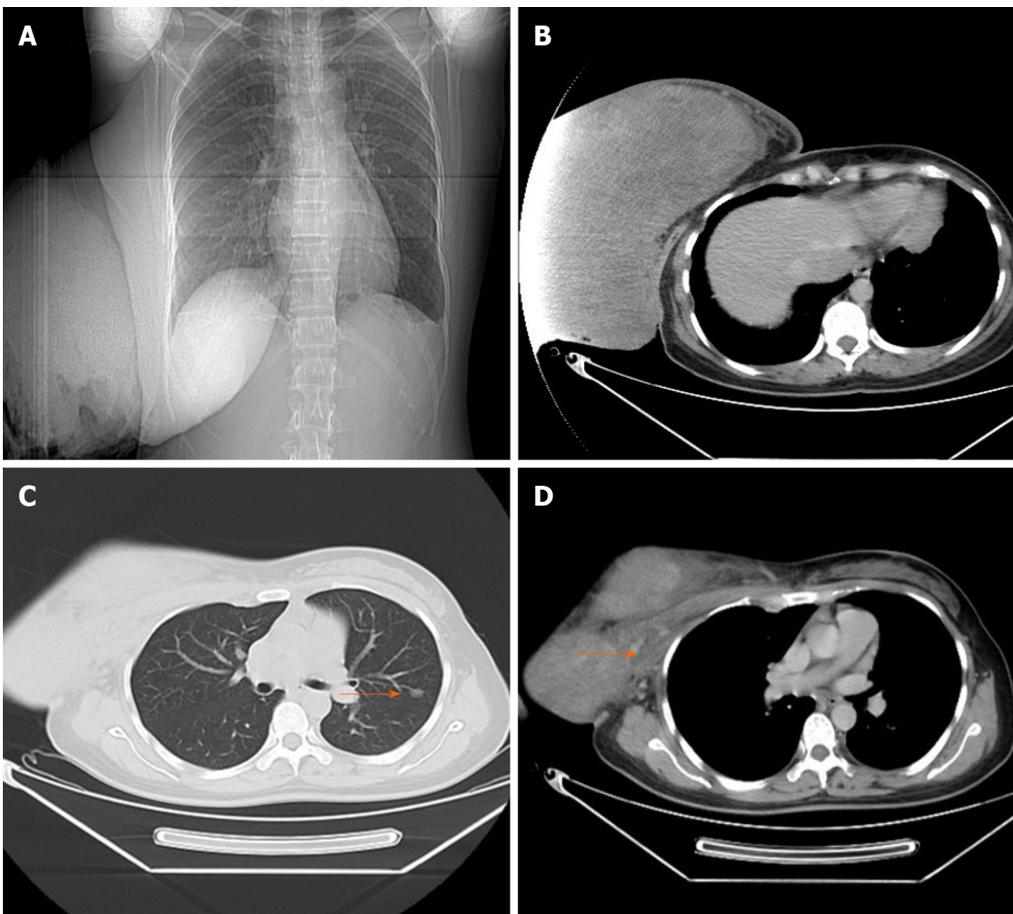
Preoperative radiologic evaluation. A and B: Chest computed tomography showed a huge mass; C: A pulmonary nodule was seen in the left lung (arrowheads); and D: Preoperative computed tomography showed that there was no clearance between the mass and pectoralis major (arrowheads).
